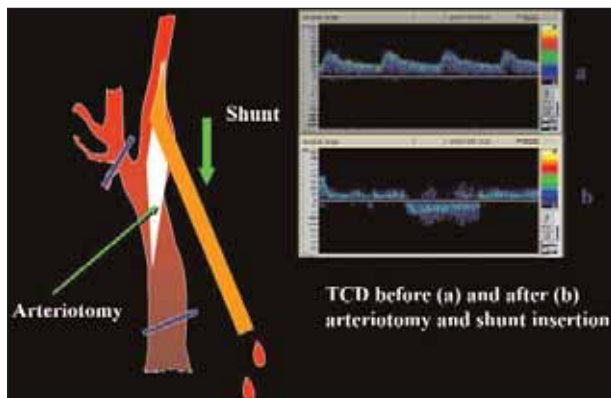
Observation during open carotid endarterectomy using transcranial Doppler monitoring.
